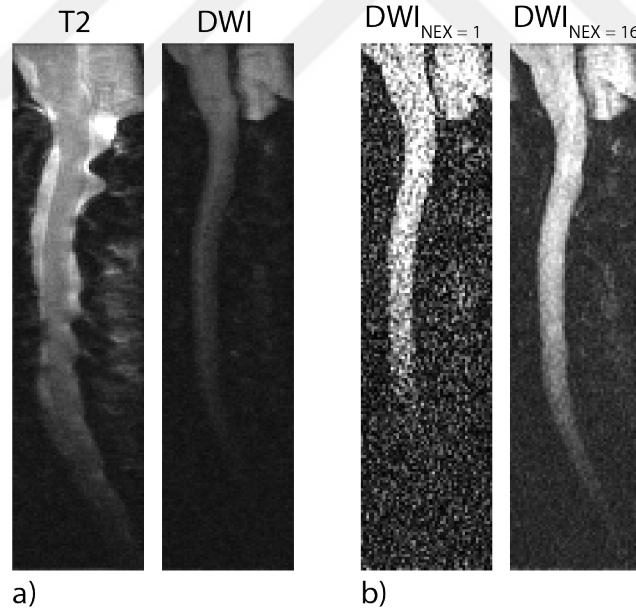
Comparison of signal levels. For each subfigure, the images are displayed with identical gray-scale windowing. a) DWI signal level is significantly lower than the T2-weighted signal level. b) To obtain a reasonable SNR, multiple acquisitions have to be averaged in DWI. NEX= 1 image fails to provide a high-quality image, whereas averaging of NEX= 16 acquisitions provides 4 times increased SNR.
